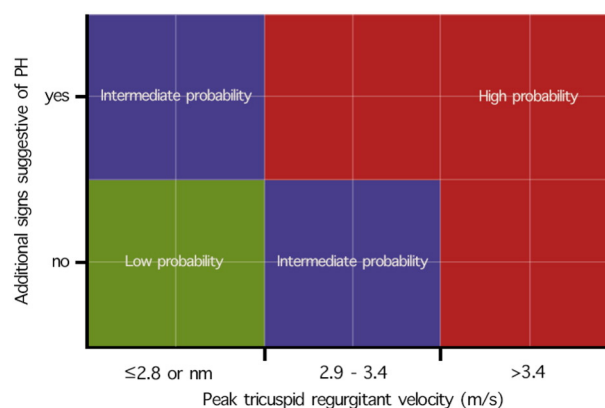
Echocardiographic probability of pulmonary hypertension (PH) according to the updated ESC/ERS PH guidelines (2015). Classification according to the presence of additional PH signs is described in the Methods section. Nm: not measurable.
